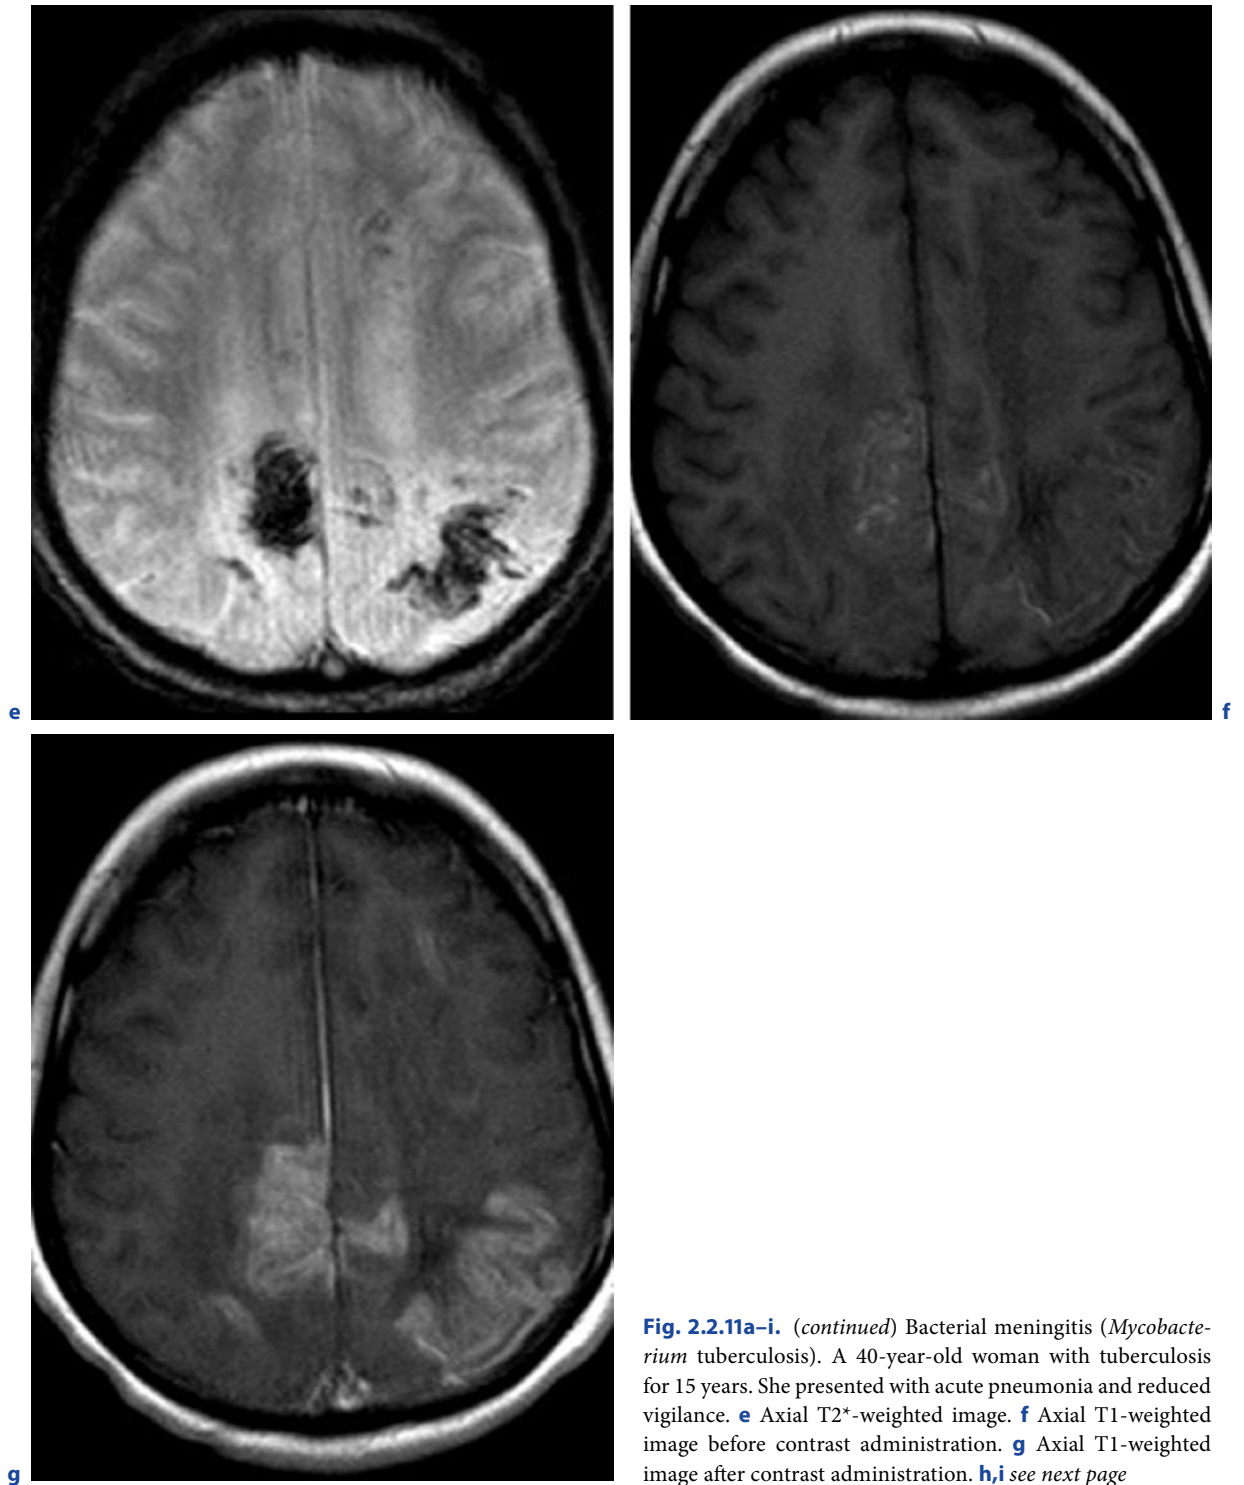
(continued) Bacterial meningitis (*Mycobacterium tuberculosis*). A 40-year-old woman with tuberculosis for 15 years. She presented with acute pneumonia and reduced vigilance. e Axial T2*-weighted image. f Axial T1-weighted image before contrast administration. g Axial T1-weighted image after contrast administration. h,i see next page
